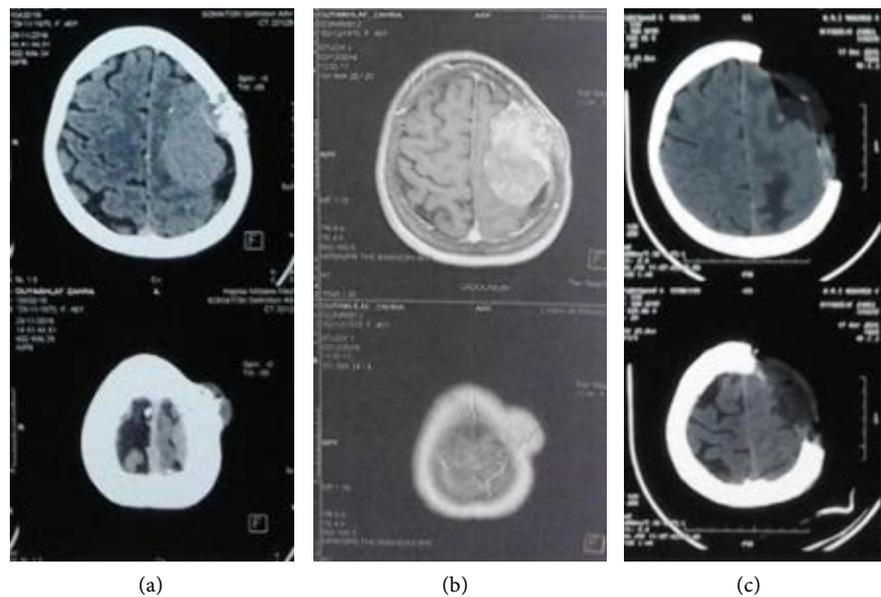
(a): Pre-operative brain CT-scan showing an aggressive left parietal lesion spontaneously hyperdense. (b): Brain MRI with the same lesion, enhanced heterogeneously after gadolinium injection with an infiltration of the bone and the subcutaneous cell tissue. (c): Post-operative CT-scan showing the large and total removal of the tumor and the loco-regional invasion of the bone.
